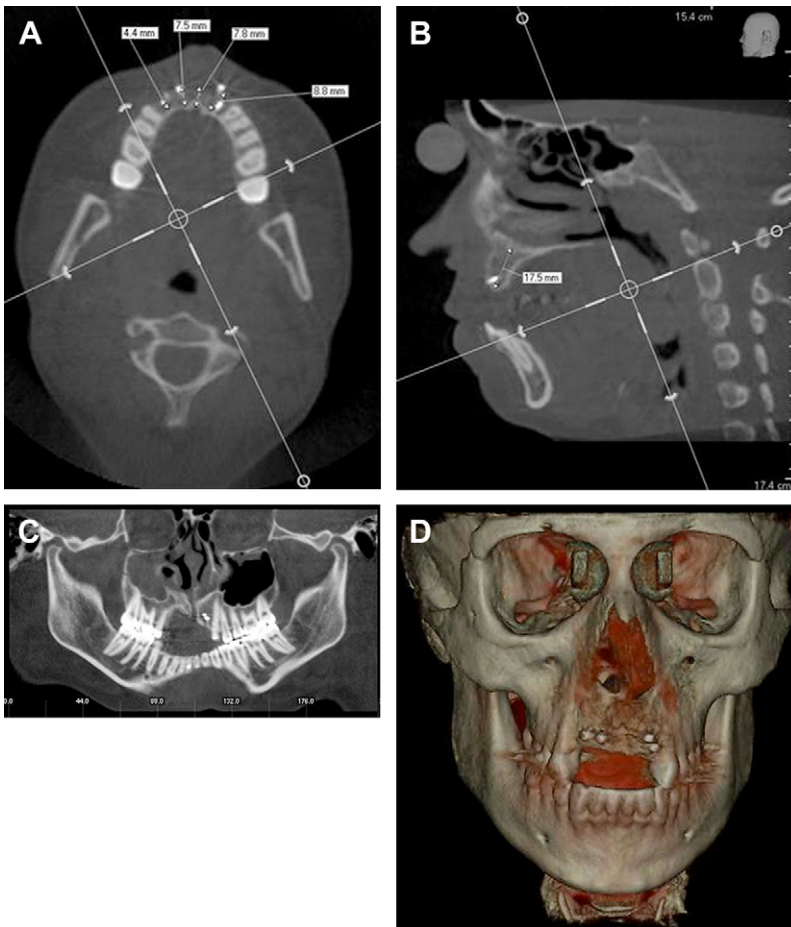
Cone-beam CT. (A) Axial image from cone-beam CT in a patient with repaired dentoalveolar fractures of the anterior maxilla. Although image quality is lower than that for standard CT, and soft tissue is not evaluated, bone structures can still be accurately measured. (B) Multiplanar reformatted images are available, just as with standard CT. (C) Curved panoramic reformats may be useful for surgeons accustomed to panoramic radiographs. (D) Surface renderings do not have the same level of detail available from standard CT, but are usually adequate for surgical planning. (Courtesy of BJ Costello.)
